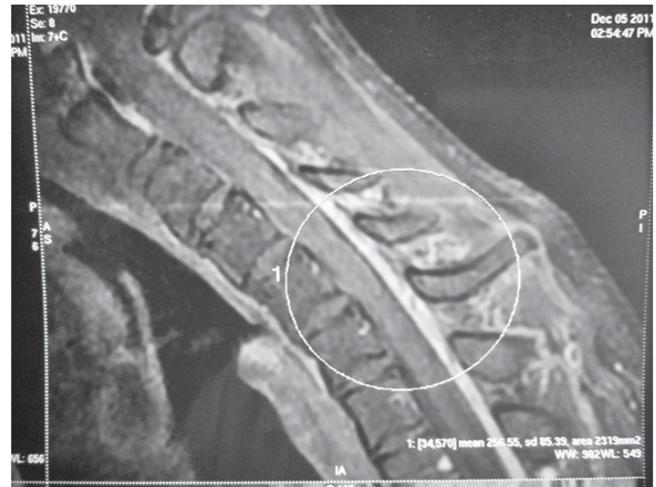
Showing the Mass in MRI
